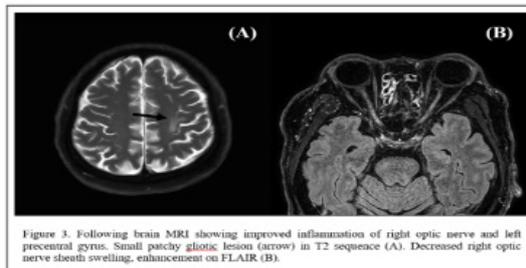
Following brain MRI showing improved inflammation of right optic nerve and left precentral gyrus. Small patchy gliotic lesion (arrow) in T2 sequence (A). Decreased right optic nerve sheath swelling, enhancement on FLAIR (B).
